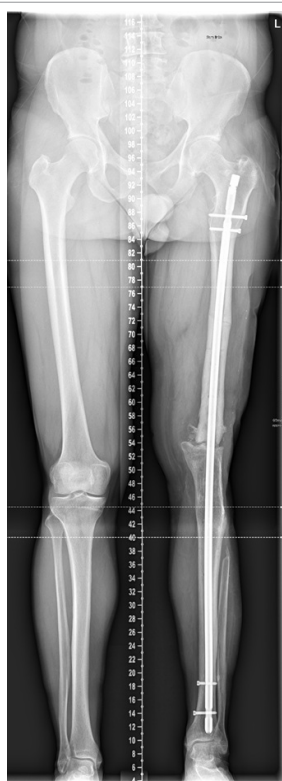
Case 1 – X-ray a.p. views 20 years after initial trauma, knee arthrodesis nail after refracture and infection treatment.
